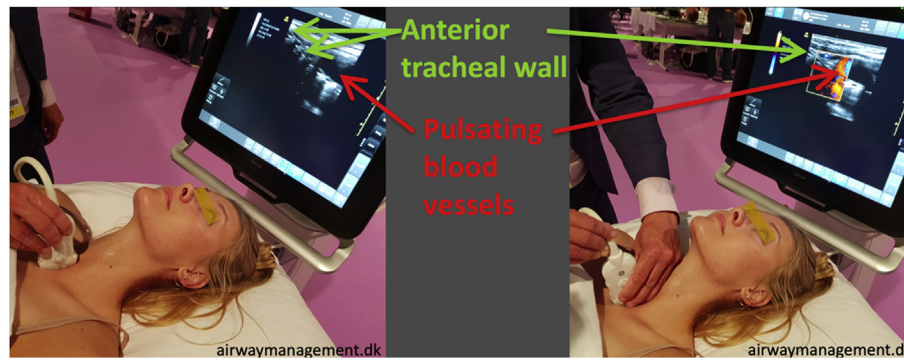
Left: longitudinal ultrasound scan of the neck as part of a routine scan to identify the cricothyroid membrane with the “String of pearls” method. The transducer is in the sagittal midline over the caudal part of the trachea. The anterior part of the tracheal rings are seen as “dark pearls on a white string”. A large pulsating blood-vessel is seen superficial to the midline of the caudal part of the trachea. Right: same view but with colour – Doppler that shows pulsation in the artery. A video is available here: https://airwaymanagement.dk/pulsating_vessels. Photos with permission from the Scandinavian Airway management course, www.airwaymanagement.dk.
